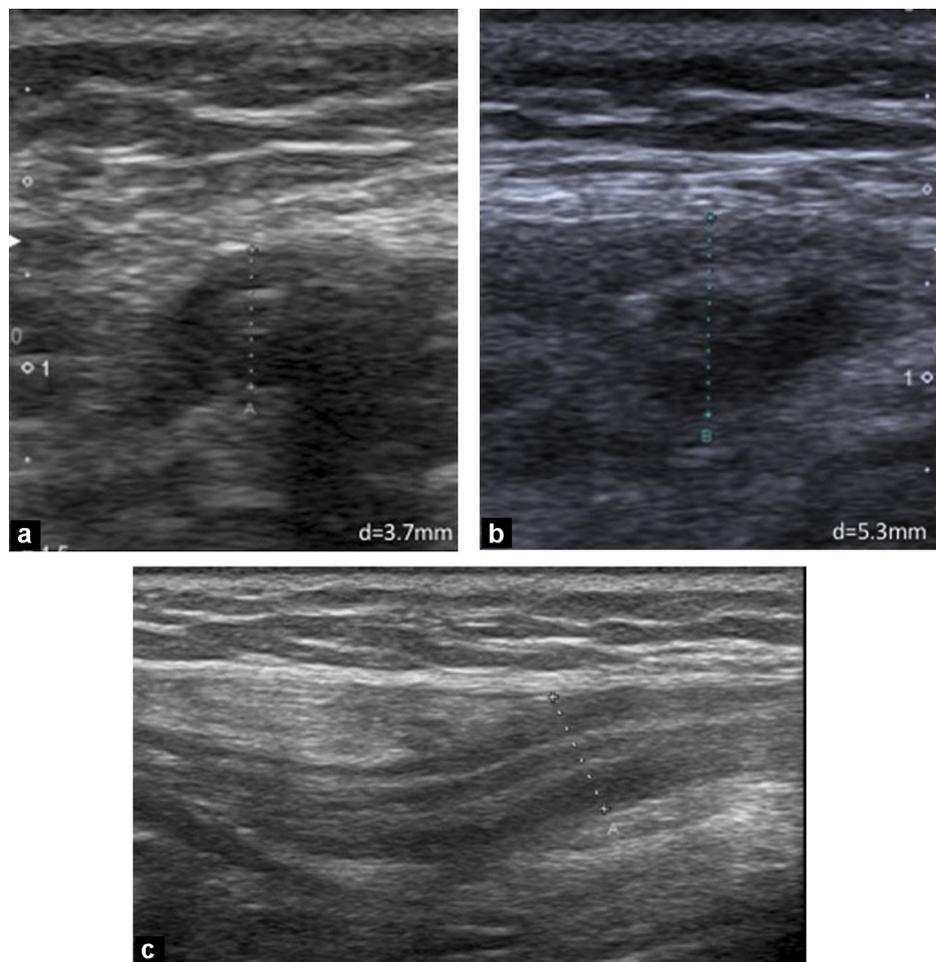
4-year-old boy with severe hemophilia A presenting with left inguinal pain without trauma. Ultrasound images in the transverse plane of the right (A) and left (B) spermatic cord show a thickening of the left spermatic cord. Ultrasound image of the left spermatic cord in the sagittal plane (C) shows linear thickening of left spermatic cord, corresponding to spermatic cord hematoma. Ultrasound ruled out testicular torsion and surgery was avoided. Symptoms resolved within 24 hours after clotting factor replacement therapy.
